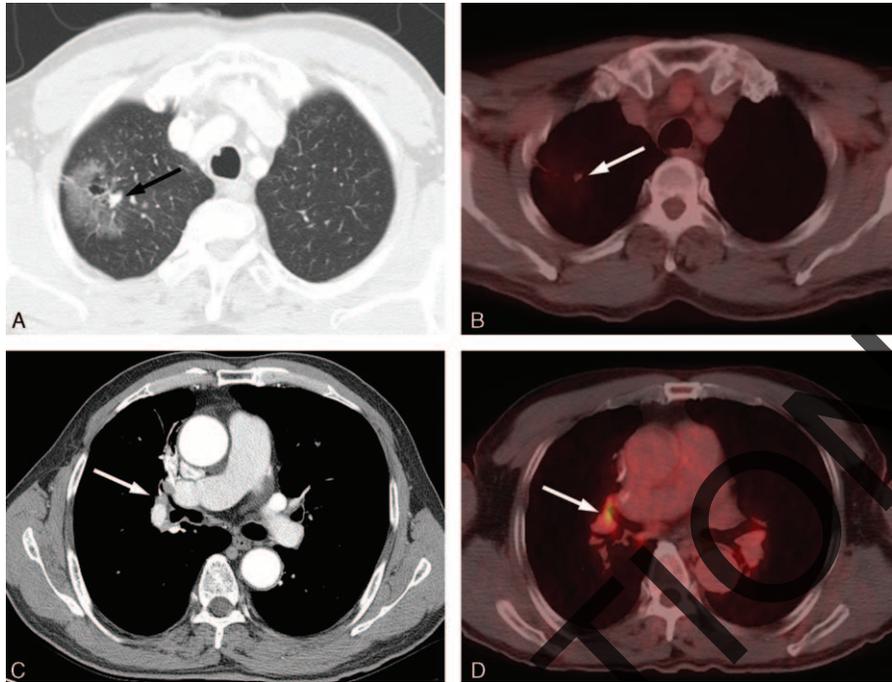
False-positive finding in PET/CT in a 57-year-old male patient with lung adenocarcinoma who underwent right upper lobectomy. (A) CT image shows a ground-glass opacity (GGO) lesion with solid portion (arrow) in the right upper lobe (GGO proportion: 83%, Group II). (B) PET/CT image shows a GGO lesion with faint fluorodeoxy glucose (FDG) uptake (arrow) with an SUVmax of 1.8. (C) Surveillance CT scan performed 12 months after lobectomy shows several right peribronchial lymph nodes measuring <1 cm in short diameter (arrow). (D) Surveillance PET/CT scan performed at the same day with surveillance CT shows right peribronchial lymph node (arrow) with an SUVmax of 4.8. Endobronchial ultrasound-guided aspiration biopsy for peribronchial lymph nodes revealed no tumor involvement. The patients are followed postoperatively for >7 years without evidence of recurrence. FDG = fluorodeoxy glucose, GGO = ground-glass opacity, PET/CT = positron emission tomography/computed tomography, SUVmax = maximum standardized uptake value.
